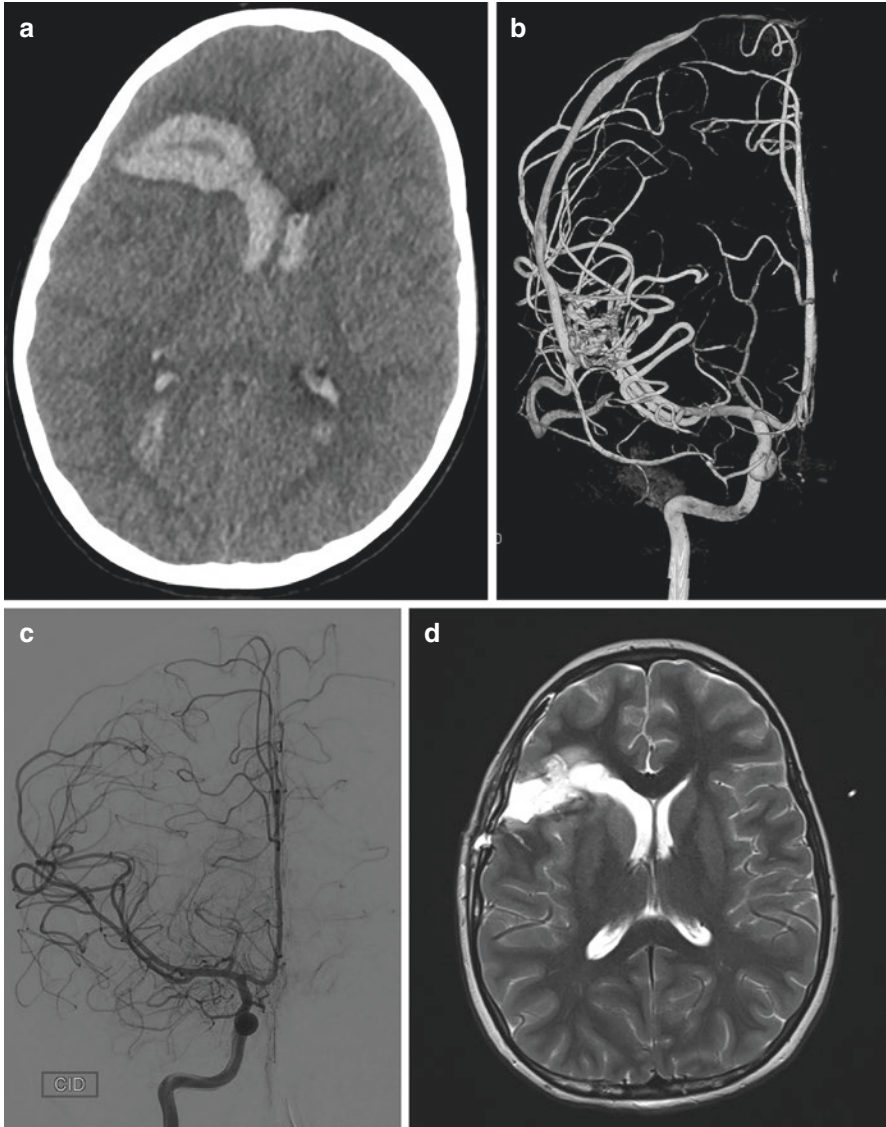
6-year-old left-handed boy with an episode of sudden loss of consciousness whilst playing computer games. Quickly deteriorated with hemiplegia and dilated pupil. He was intubated, sedated and hospitalized. CT revealed a massive right-sided intracerebral and intraventricular hemorrhage (a) with effacement of the basal cisterns and midline shift. DSA showed a medium-sized AVM in eloquent cortex (Spetzler-Martin grade 3) with a superficial venous drainage that was filled by feeding arteries coming off the middle cerebral artery (b). He underwent emergency surgery and because of an ongoing hemorrhage and extremely raised intracranial pressure, we decided to resect the AVM as we evacuated the hematoma. A complete resection of the AVM was verified by a postoperative DSA (c). 6 months after surgery, he had already made an excellent recovery (mRS 1) and an MRI showed no residual lesion (d)
